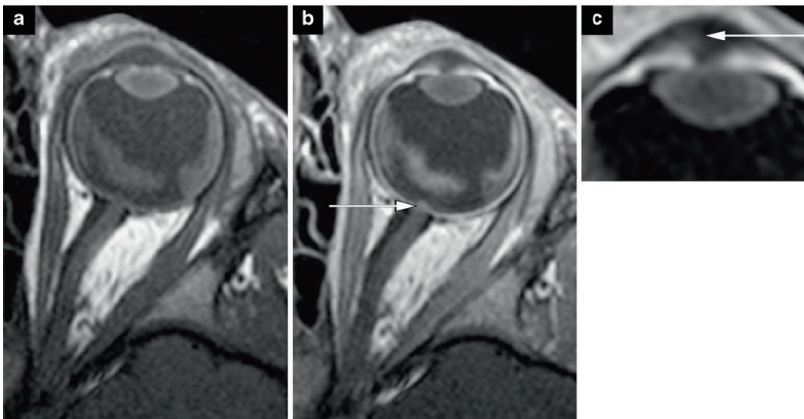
Pre- (a) and postcontrast (b) transaxial T1-weighted (374/14) MR images show small nodular enhancement at the optic nerve disk (arrow), which represents superficial optic nerve invasion by intraocular tumor seeding (predilection site). c Abnormal contrast enhancement of the anterior eye segment combined with macroscopic tumor seedings (arrow)
